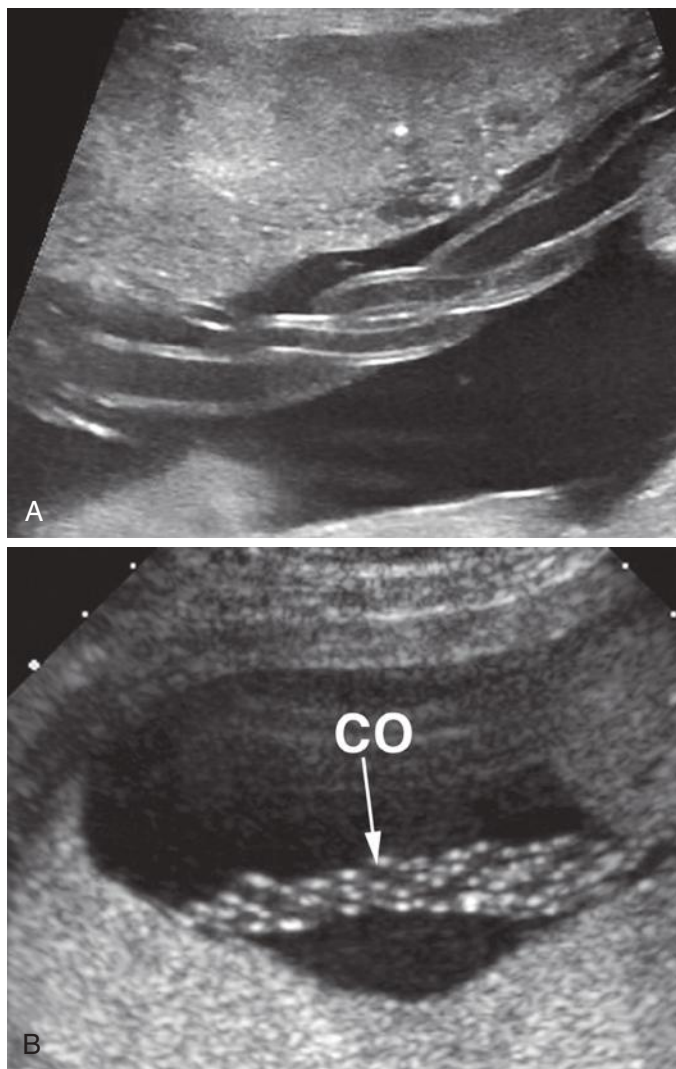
A, Longitudinal sonogram of a three-vessel umbilical cord with a typical amount of coiling. B, Longitudinal sonogram of a three-vessel umbilical cord (CO) with a greater than usual amount of coiling (there is an issue as to whether this is a variant or an abnormal circumstance).
